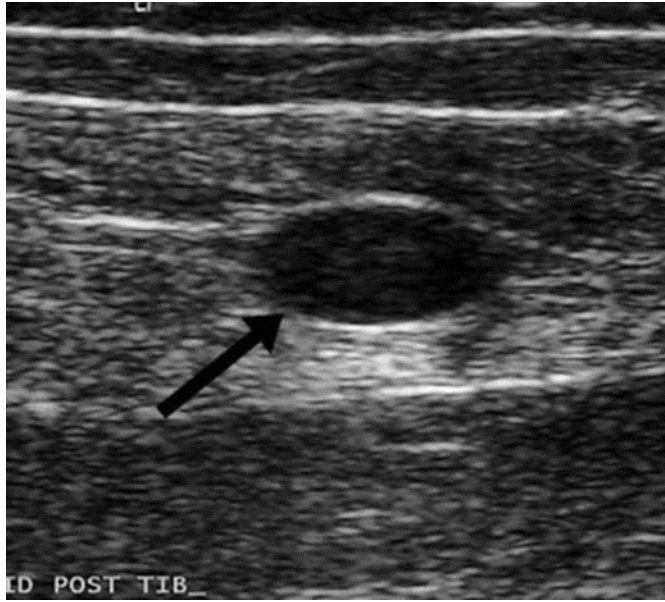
Ultrasound image of the schwannoma. Arrow indicates solid hypoechoic nodule displacing muscle.
